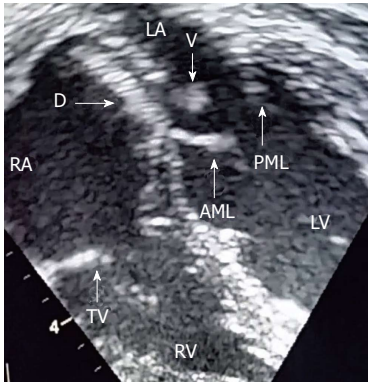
Two dimensional echocardiography image showing a large mobile vegetation (V) attached to the lower surface of an Amplatzer device (D) near the mitral valve. AML: Anterior mitral leaflet; PML: Posterior mitral leaflet; LV: Left ventricle; RV: Right ventricle; LA: Left atrium; TV: Tricuspid valve; RA: Right atrium.
